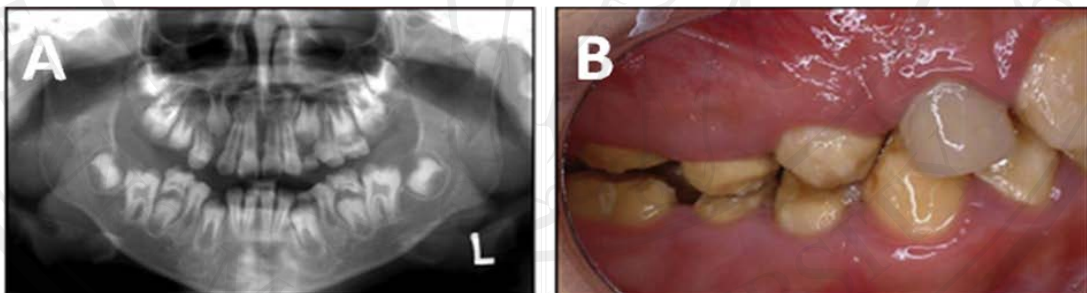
(A) Normal enamel thickness of unerupted teeth shown in the panoramic radiograph, (B) but the enamel is soft in consistency. The teeth are sensitive to thermal changes (Kim et al., 2008).
